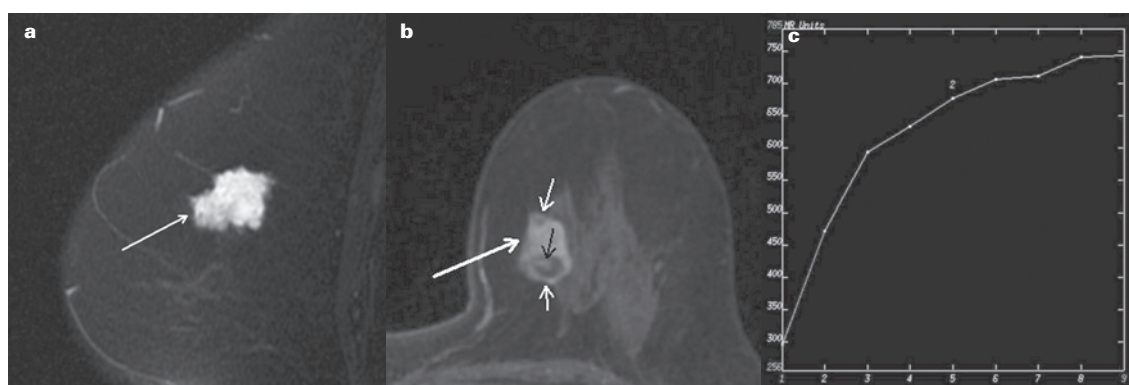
A 42-year-old woman with FAs in her left breast. The oval mass (arrow) with circumscribed margin and strong high-signal intensity on the sagittal fat-saturated T2-weighted images (a) shows homogeneous enhancement (arrow) in the delayed phase (b) and rapid initial increase enhancement and a plateau enhancement pattern (c).
